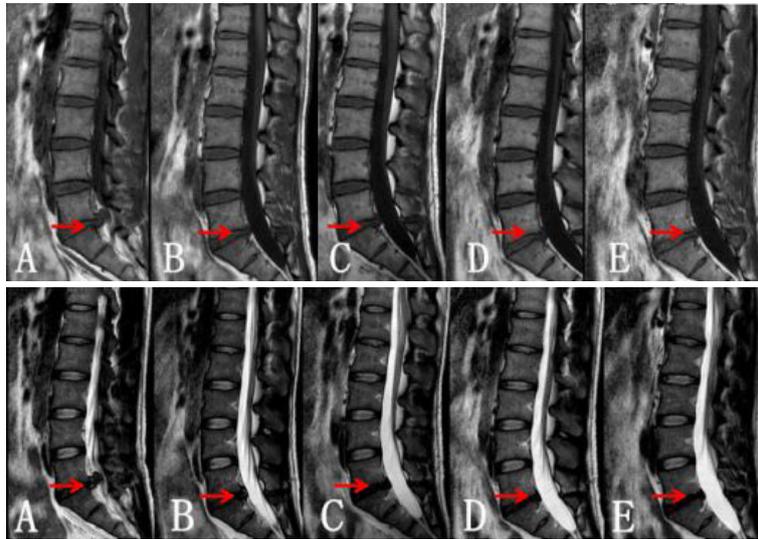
MRI T1 image and Fig.2 MRI T2 image (red arrow represents the operative area)
